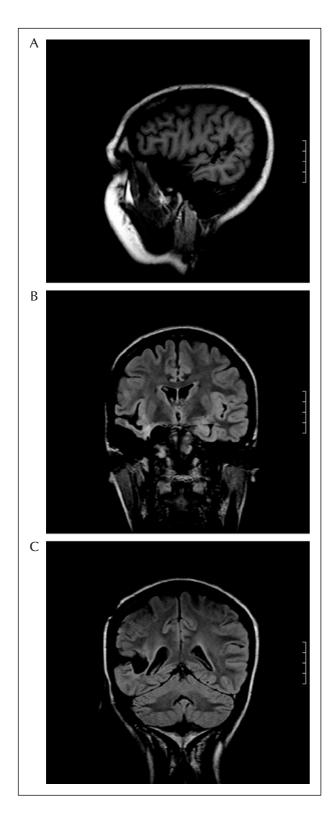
Postoperative MRI showing extension of lesionectomy and associated anterior right anterior temporal resection.
